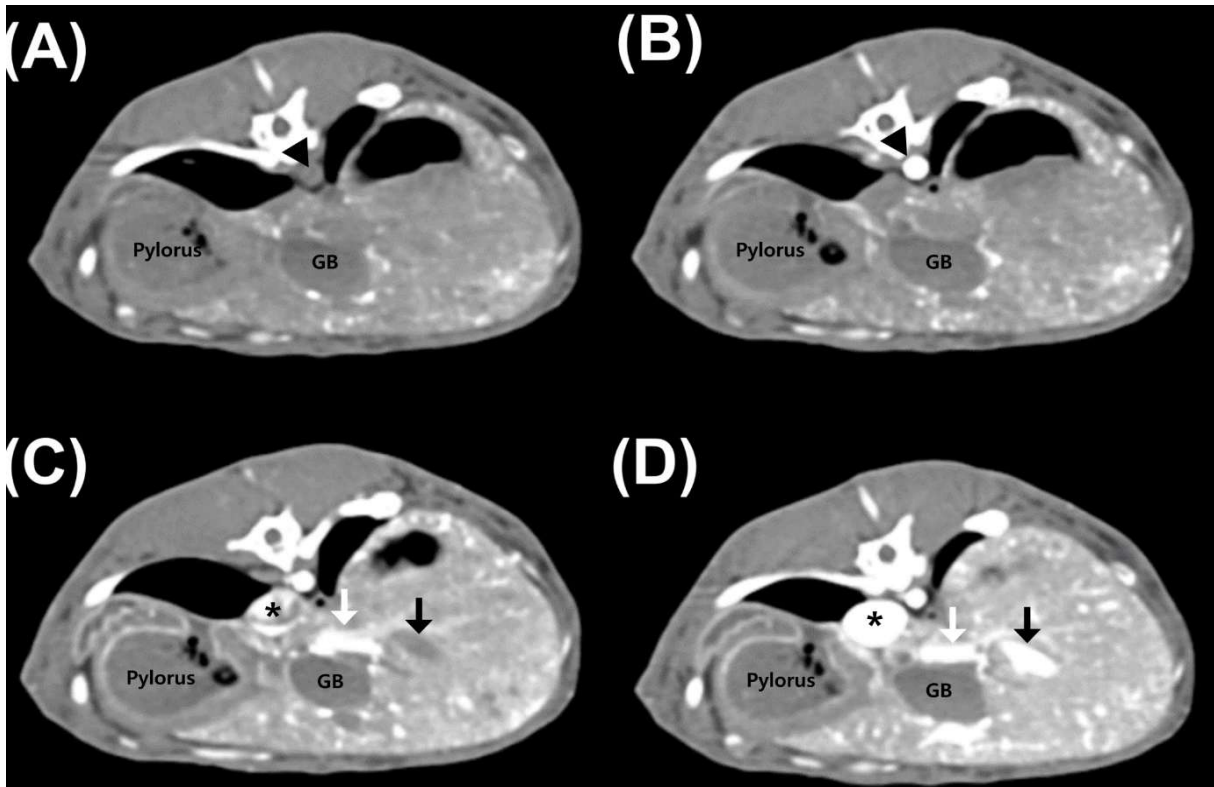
CT images showing: (A): Pre-contrast phase showing hyperattenuated lipiodol deposition (arrow-head) in the hepatic parenchyma, GB; gall bladder. (B): Arterial phase with aortic contrast opacification (arrow-head); hepatic parenchymal enhancement is minimal, reflecting predominant portal perfusion in normal liver tissue. (C): Portal venous phase showing complete opacification of the portal vein (white arrow) and partial filling of the caudal vena cava (star); hepatic parenchyma enhancement is lower than pre-embolization. (D): Delayed phase with full contrast in caudal vena cava (star) and intrahepatic vein (black arrow); overall hepatic enhancement is decreased, reflecting perfusion reduction post-embolization. Portal vein is shown by the white arrow.
